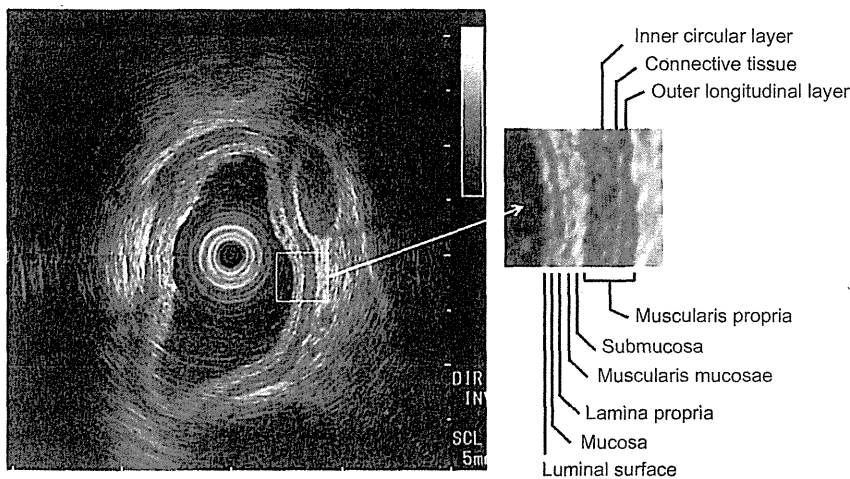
Endoscopic ultrasonography (EUS) image of the normal esophageal wall by 20 MHz miniprobe demonstrates a nine-layered structure (arrow). The first five layers correspond to the echogenic luminal surface (high echo), mucosa (low echo), lamina propria (high echo), muscularis mucosae (low echo), submucosa (high echo). Next are inner circular (low echo) and outer longitudinal (low echo) layers of muscularis propria. They are separated by a thin hyperechoic layer of the connective tissue (high echo).
